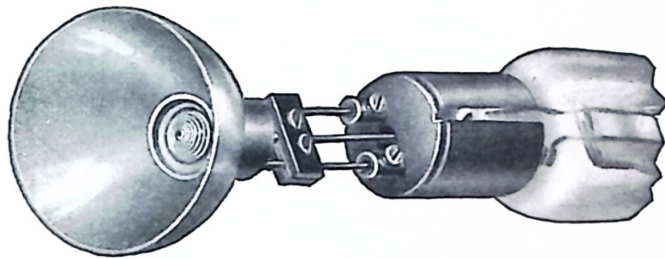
Cathode of Radiator Type Coolidge X-Ray Tube
